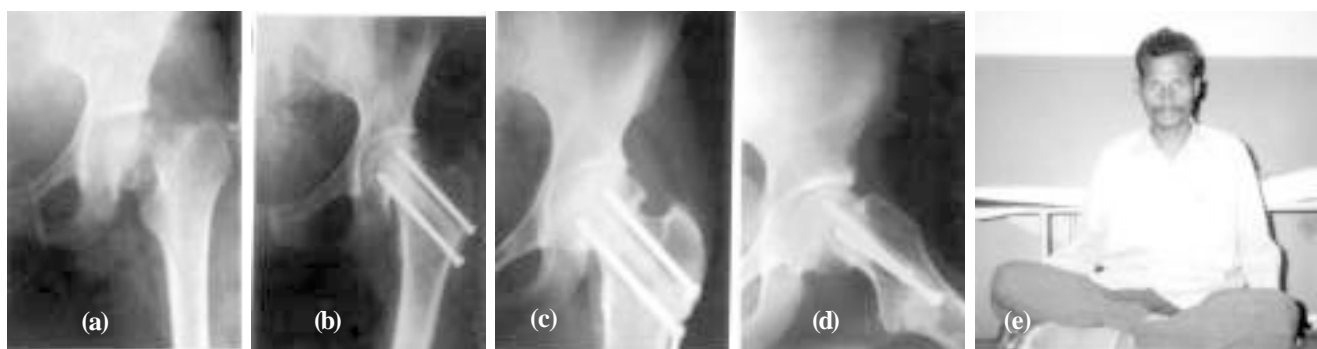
(a) Radiograph showing a united femoral neck fracture, (b) immediate post-operative after fibular grafting and screw fixation, (c, d) union after 6 months, (e) Clinical results
